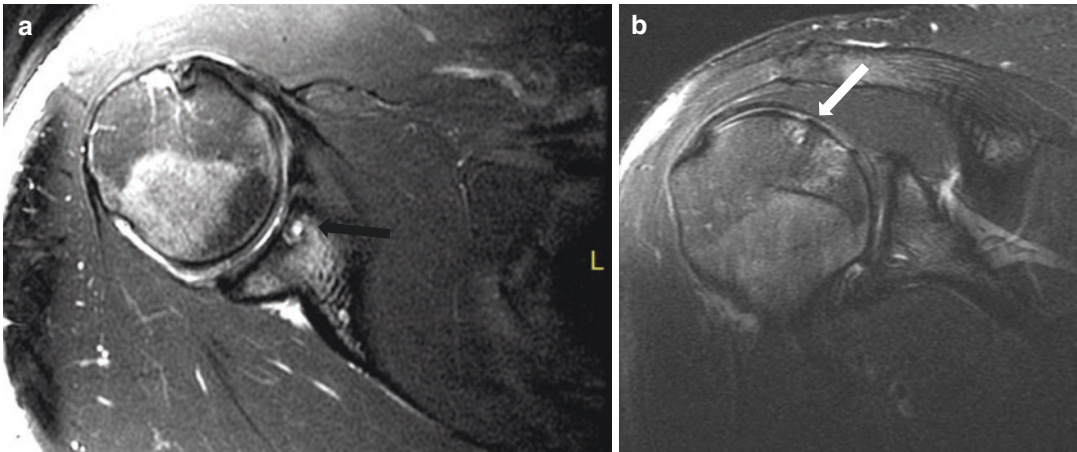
Cartilage loss. Axial (a) and coronal oblique (b) fat-suppressed fluid-sensitive MR images demonstrate cartilage loss along the glenoid (black arrow) and humeral head (white arrow) with subchondral marrow edema
